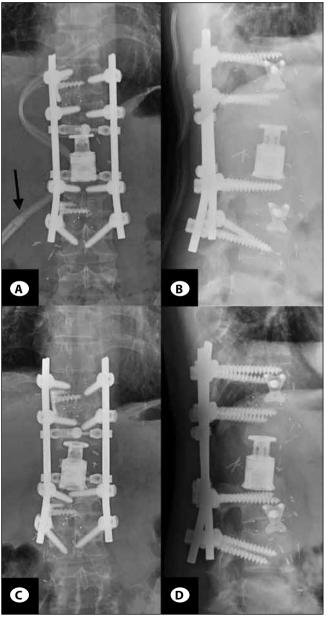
Early postoperative (A and B) and last follow up (C and D) AP and Lateral X-Ray films demonstrate accurate localization and appropriate hardware integrity.
